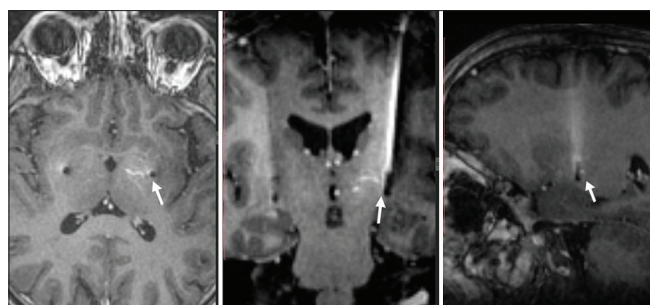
Postoperative MRI revealing the lead position related to the branches of the DVA (white arrows)
